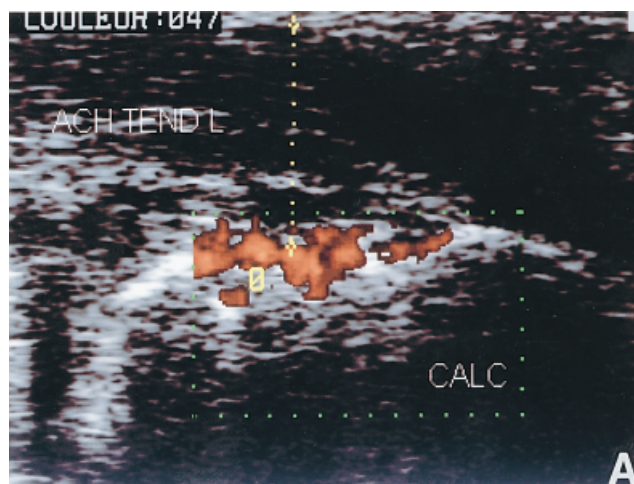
Ultrasonography of left (L) calcaneal (CALC) enthesitis in a spondylarthropathy patient treated with infliximab. A, Baseline. Power Doppler sonography shows hypoechoic thickening of the Achilles tendon (ACH TEND) at the entheses, with increased blood flow. B, Fourteen weeks after initiation of infliximab treatment. Ultrasonography shows improvement of the echoic pattern of the Achilles tendon and disappearance of periosteal vascularity.
